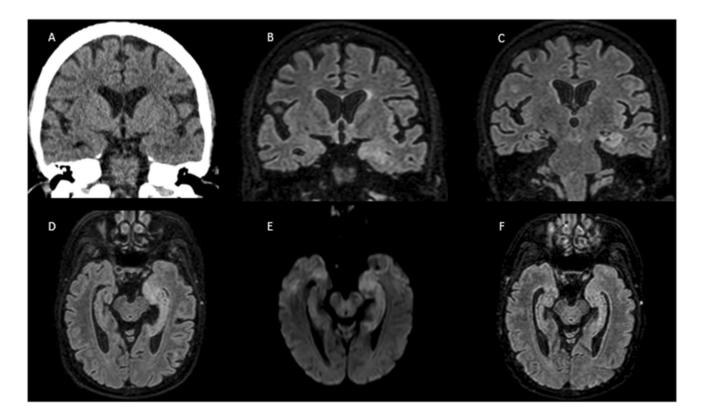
Case 6. Limbic encephalitis associated with double onconeural antibodies positivity (anti-Hu and anti-SOX1) and lung neuroendocrine cancer. Brain CT revealed partial sulcal effacement of the left temporal lobe, adjacent to the temporal horn A. MRI brain showed FLAIR hyperintense signal in left hippocampal-amygdala formation B-C, coronal plane; D, axial plane). Follow up MRI revealed mesial temporal lobe atrophic regression on DWI E and FLAIR F axial planes
